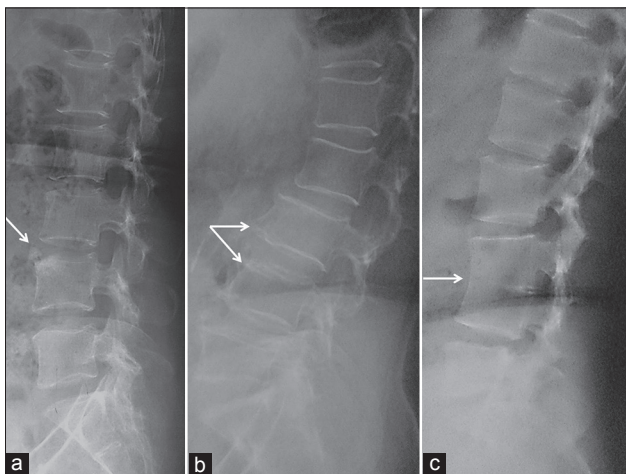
Vertebral deformities. Lateral radiographs of spine show limbus vertebra (a), degenerative spondylosis (b) and block vertebrae (c). These should not be mistaken for fractures. In degenerative spondylosis (b), the decrease in height is less than 20% and parallelism of end-plates is maintained
